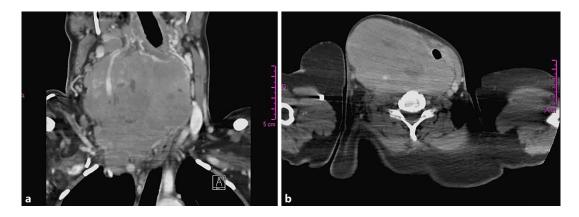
CT scans of the neck. a Coronal view. A huge neck soft tissue mass can be seen, with compressive signs/a mass effect and vascular encasement, as well as a few pathological lymph nodes, likely of right thyroid origin, with features highly suggestive of a neoplastic lesion. b Axial view. There is a sizable space-occupying mass lesion most likely originating from the right thyroid gland and causing disfigurement and bulging of the right side of the neck and markedly displacing the trachea, esophagus, and left carotid sheath to the contralateral (left) side.
